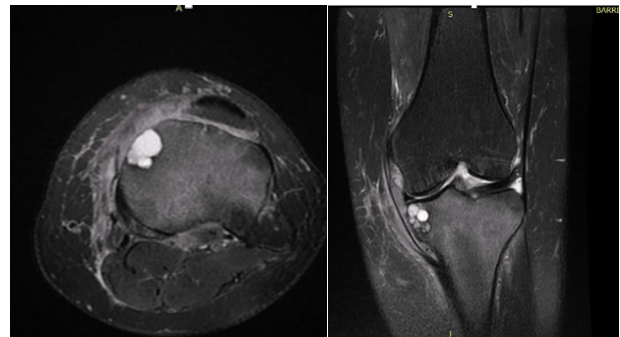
MRI of the left knee in T2 mapping sequence in axial and coronal view showing a cystic lesion in the medial tibial plateau and a diffuse increase in the signal intensity of the tibia.
